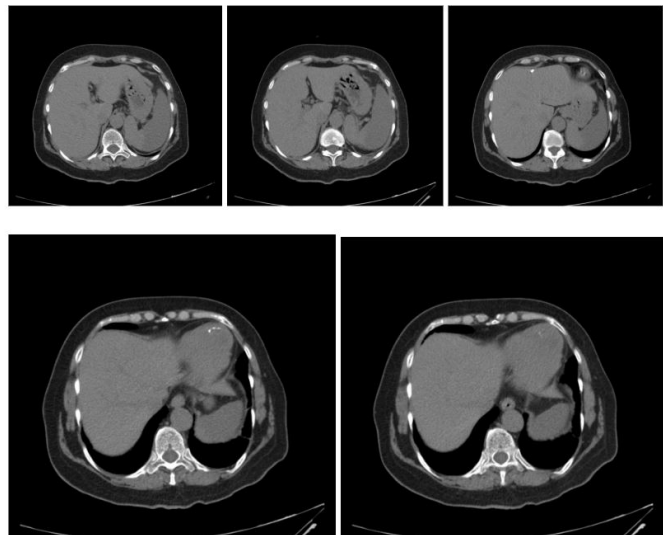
Normally monitored spleen image in the abdominal CT taken during hospitalization of the patient
